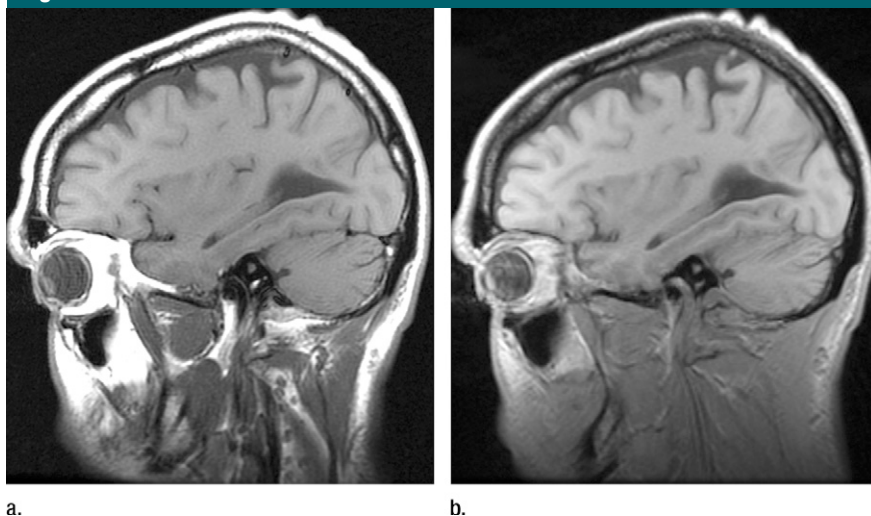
(a) Typical 4.8-mm directly acquired right parasagittal image section obtained with high-SAR 2D clinical spin-echo T1-weighted sequence and (b) 4.8-mm-thick section (reconstructed from three 1.6-mm sections) obtained with ultra-low-SAR 3D SPGR T1-weighted sequence. Both were acquired with $0.8 \times 1.0 \text{ mm}^2$ in-plane resolution from the same location and in the same subject as in Figures 2 and 3.
